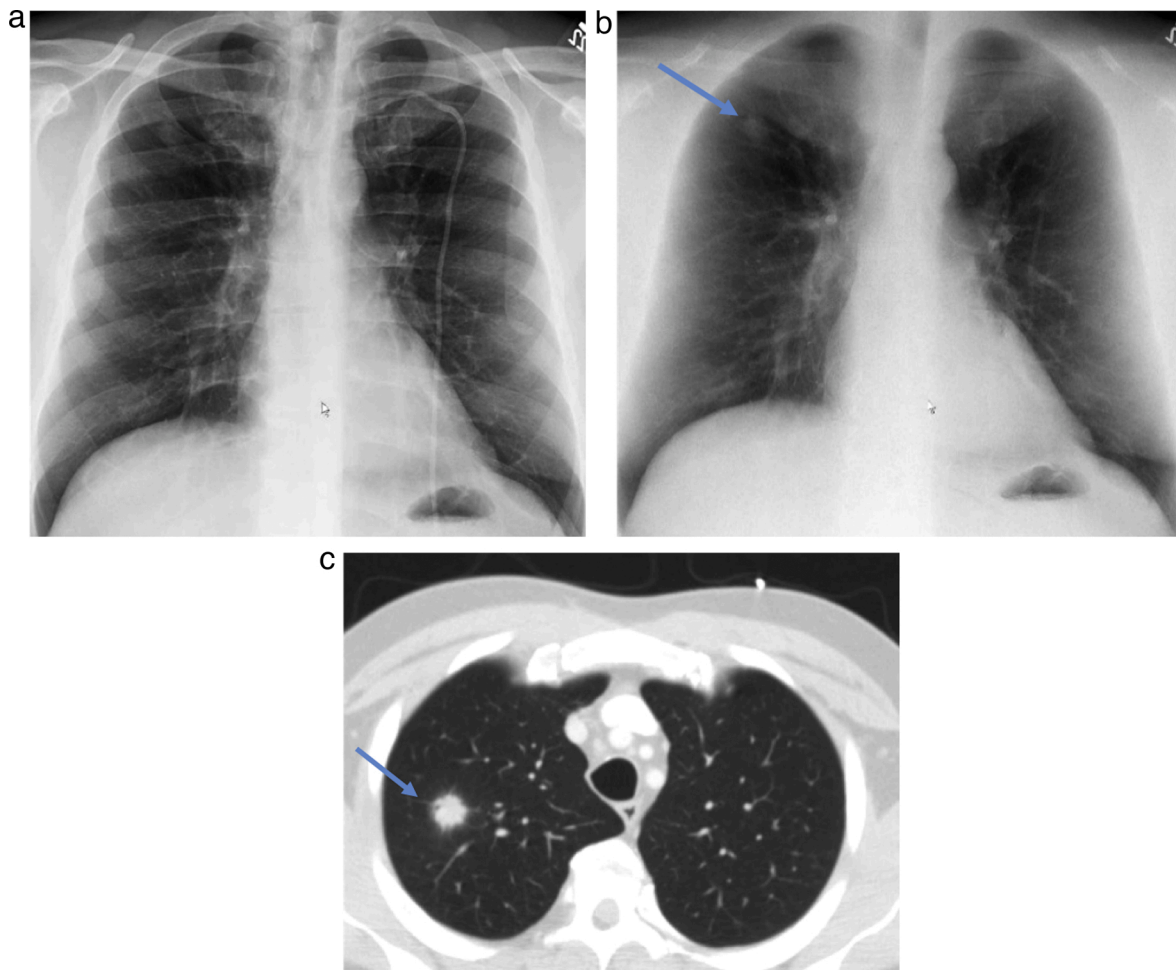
Improved pulmonary nodule detection in a 50-year-old male, s/p stem cell transplant with neutropenia and fever. Conventional radiograph (a) appears unremarkable, but the soft tissue image (b) shows a discrete nodular opacity posterior to the right second rib(Arrow). Subsequent CT scan(c) clearly confirms a solid nodule with subtle ground glass halo(Arrow), which was later proven to be invasive aspergillosis on culture.
